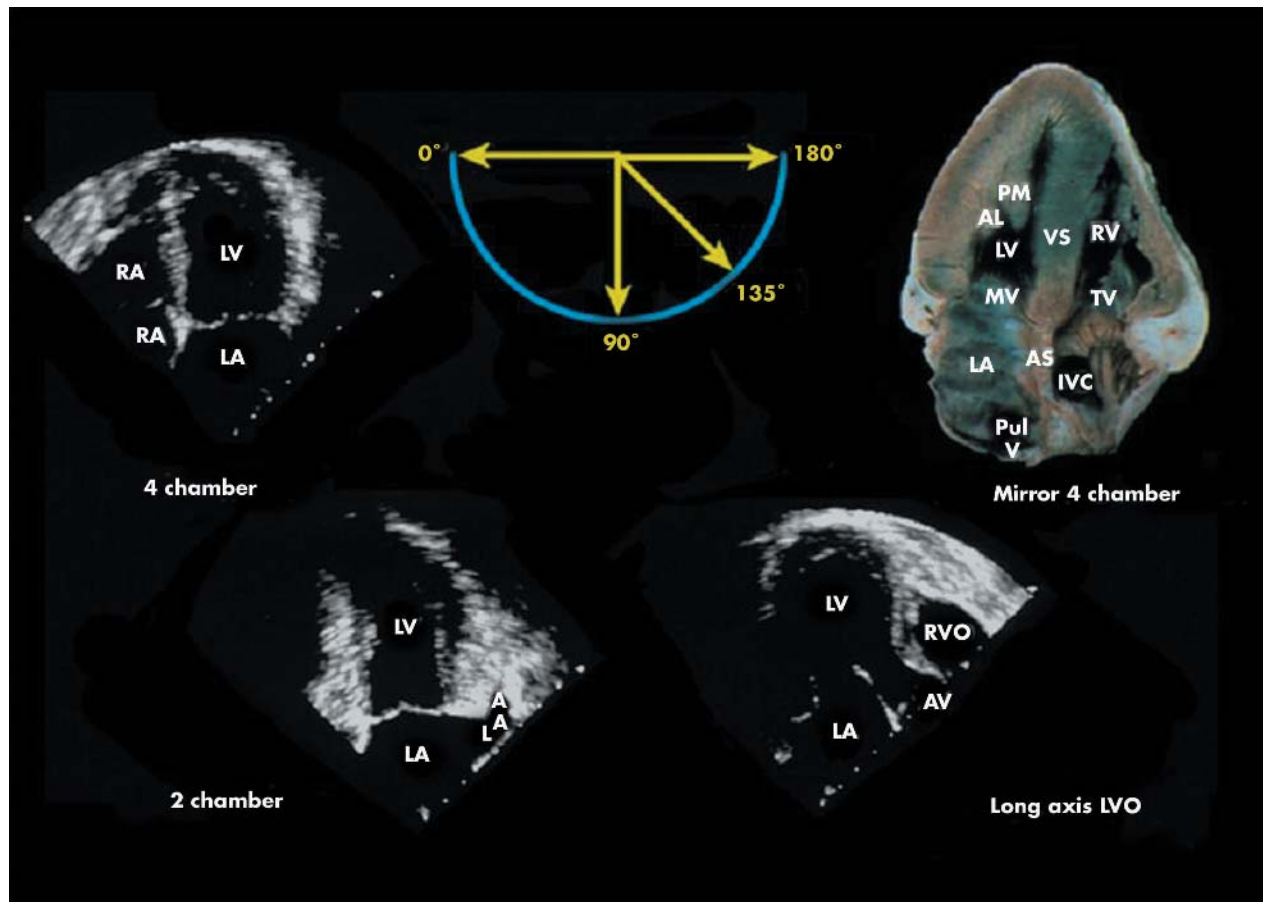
Multiplane (0° , 90° , 135° , and 180°) views obtained along the long axis of the left ventricle resembling apical views obtained during surface echocardiography. See fig 1 for explanation of abbreviations.
